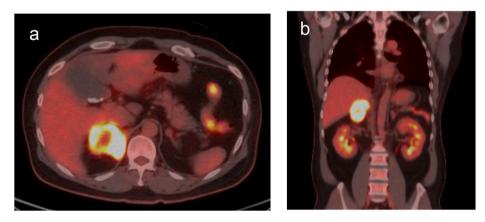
PET-CT shows fluorine-18-deoxyglucose accumulation in the right adrenal gland (a: axial, b: coronal).
